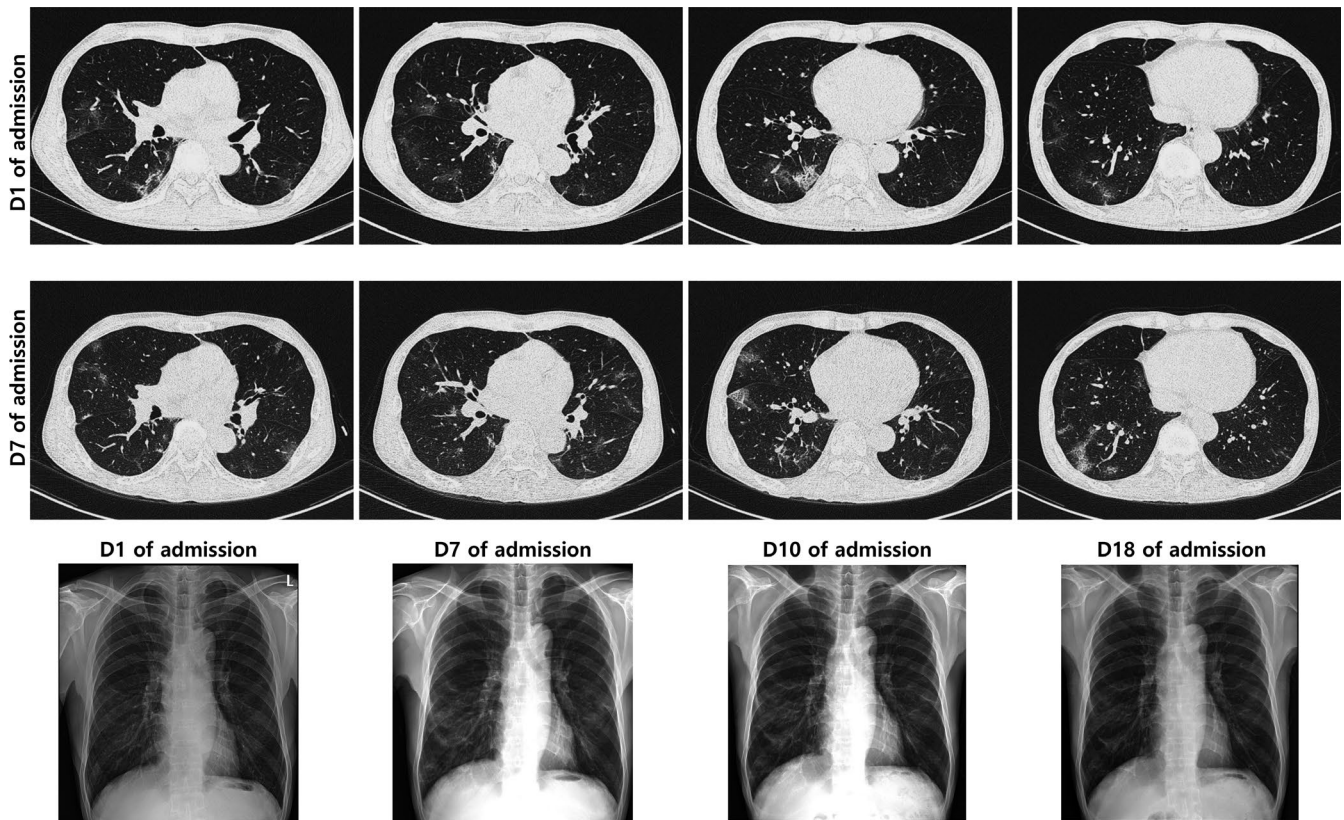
Changes in the findings of chest radiograph and chest computed tomography (CT) in Case 2. The first row shows chest CT findings on admission date (D1), and the second row shows chest CT in hospital day (D) 7. The same columns between the first and second rows show the same plane in the CT. The infiltrative lesion in both lower lung field in the chest CT was more aggravated on D7 than on D1. The last row shows the changes in the findings of chest radiograph from admission day to hospital day 18. The infiltrative lesion was aggravated in the image on D7, but it was improved on D18
